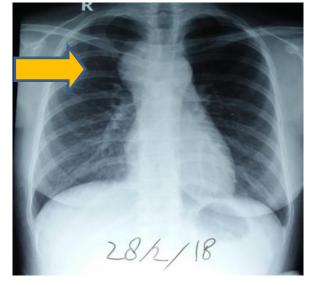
AP / lateral chest X-ray with suspected anterior mediastinal mass
